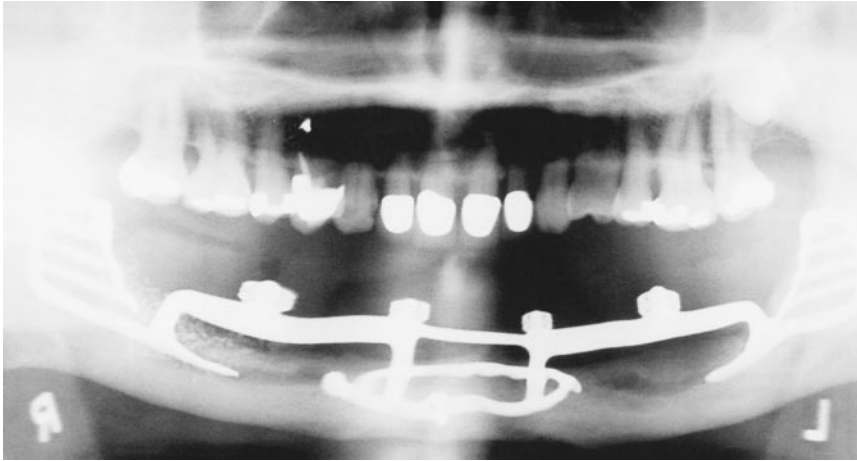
Panoramic radiograph taken post “re-entry” of lower right permucosal site showing hydroxylapatite graft material and alteration of the framework.
